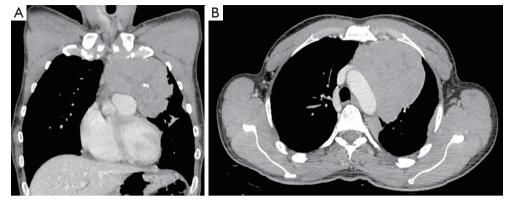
Coronal CT (A) and axial CT (B) images show mediastinal mass and a pleural lesion at diagnosis. CT, computed-tomography.
